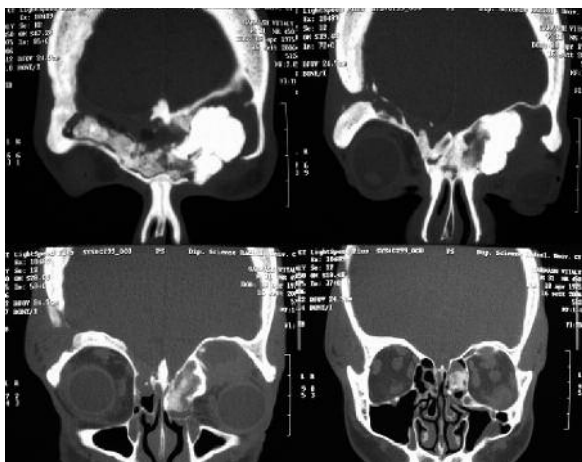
Coronal bone CT scans showing the extension of bony lesion inside the left frontal sinus and upper ethmoidal cells and the wide destruction of the left orbital roof.
